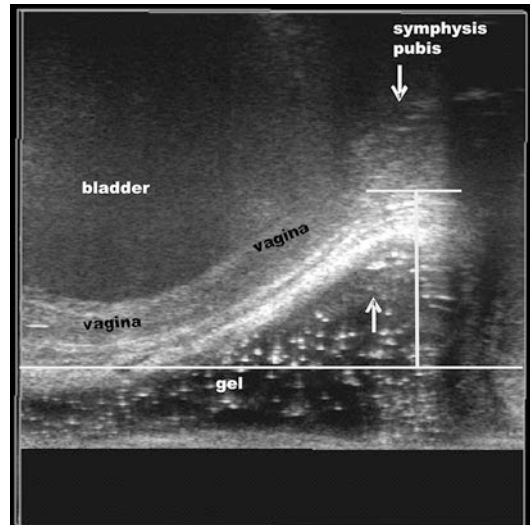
Dynamic 3-D transvaginal and transrectal ultrasonography. Using gel into the rectum – Transrectal approach Patient with rectocele (classified as grade II). Line 1 and 2 = 2 vaginal wall positions; Line 3 = depth of the rectocele
